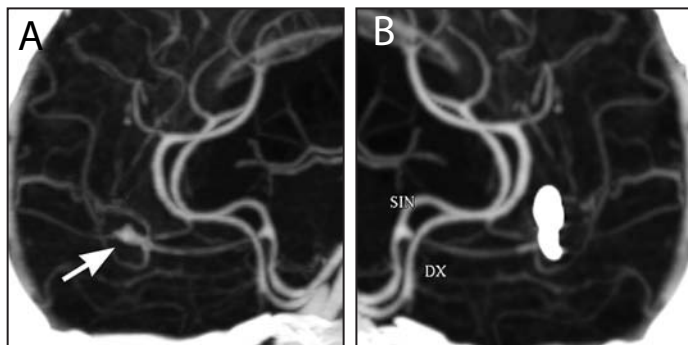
Unruptured frontobasal A2A (arrow) at the distal frontopolar artery as seen on (A) preoperative and (B) postoperative CTA (see DACA— video 5).
